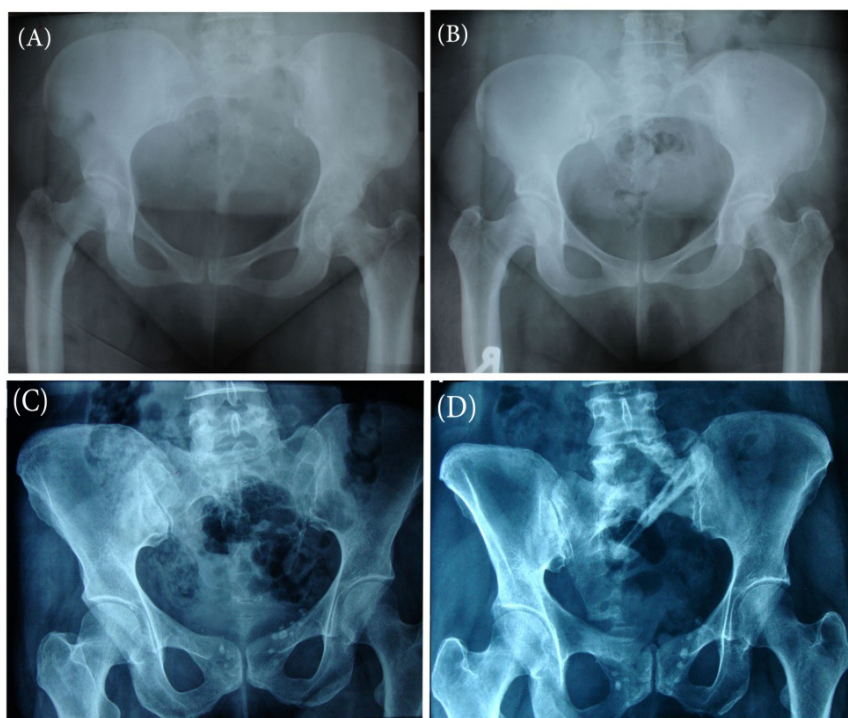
(A&B) X-ray before and after curettage and cortico cancellous bone graft of a sacral giant cell tumor (case 1); (C&D) X-ray before and after curettage and structural bone graft of a sacral giant cell tumor (case 3).
